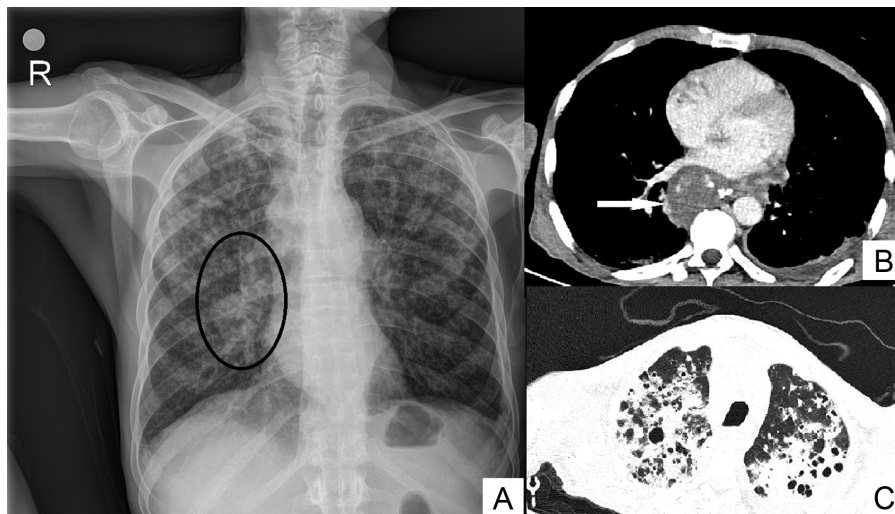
Reticulonodular densities at the upper and mid zones and right hilar prominence (A, circle) can be seen on chest X-ray (A). Right hilar fullness corresponds to a calcified lymph node on computerized tomography image (B, arrow). Consolidations, ground glass opacities, bronchiectasis, and cystic changes can be seen at bilateral upper lobes on computerized tomography image (C).
